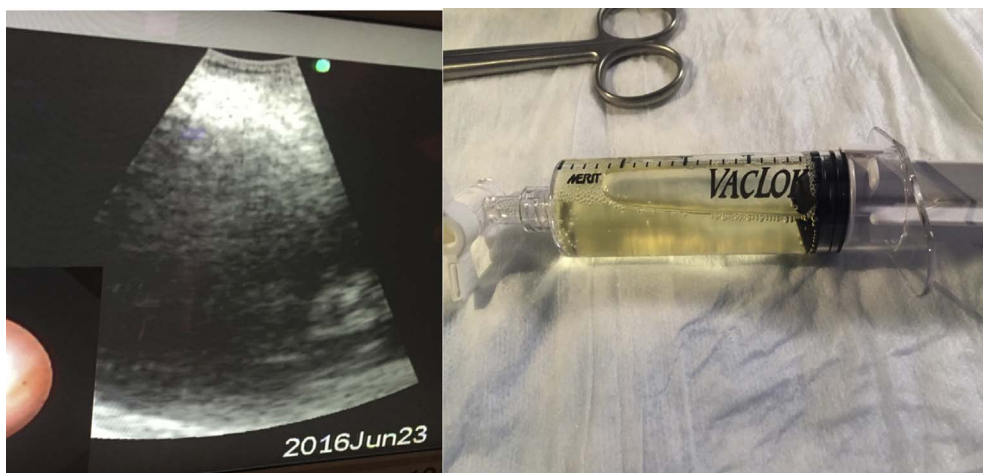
Doppler US image and syringe with fluid aspirated from the paratracheal mass.
